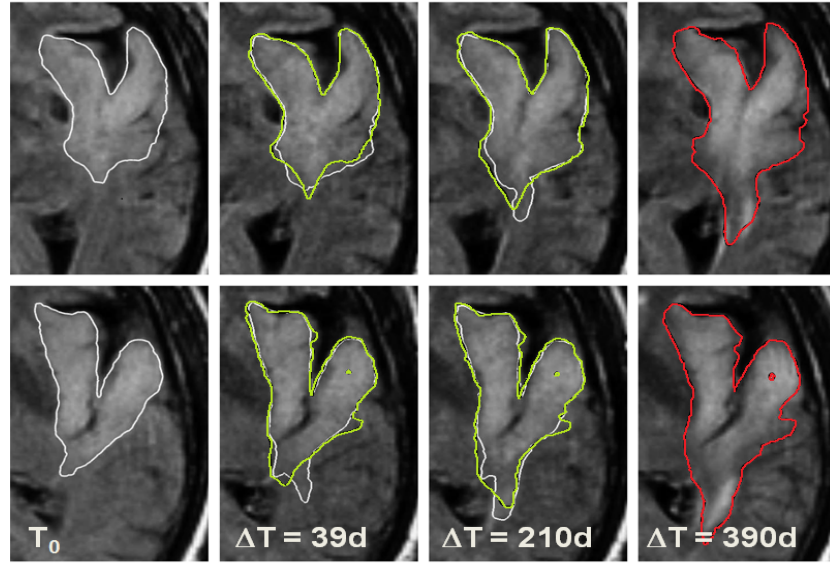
Three-dimensional evolution of tumor growth and the prediction of tumor development for a patient with a low grade glioma, using the model approximation of Konukoglu et al. [5]. Shown are two FLAIR-MRI image slices (top and bottom row) with manual tumor delineations (white) used to parameterize the growth model. Green outlines in column two and three represent results from fitting the model to observations one to three. Red outlines in the final, fourth column represent an extrapolation of the parameterized tumor model by 180 days beyond the third observation. Predictions are in good accordance with the true evolution of the tumor.
